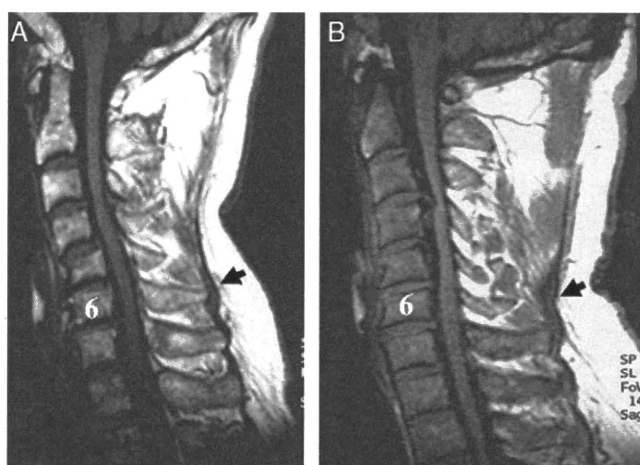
Two types of the funicular portion of the nuchal ligament attachment on T1-weighted MRI. A, C6+7 type; the funicular portion of the nuchal ligament attaches both to the C6 and C7 spinous processes. B, C7 type; the funicular portion of the nuchal ligament attaches only to the C7 spinous process.
